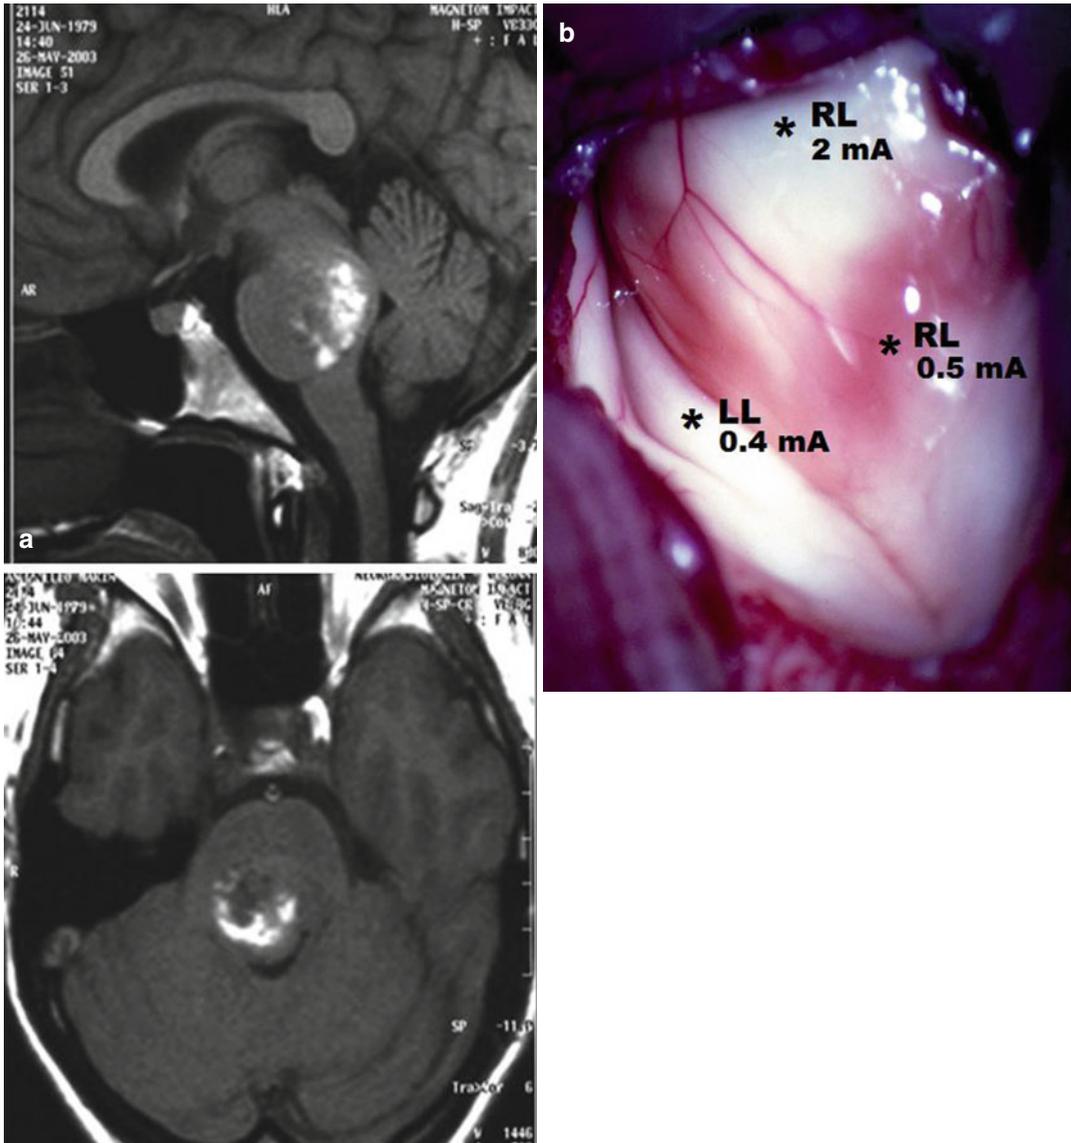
Displacement of facial nerve nuclei. (a) Sagittal and axial T1-weighted MR images of a bleeding upper pontine cavernoma. (b) Intraoperative view of the distorted floor of the fourth ventricle with no anatomical landmarks to identify the facial colliculi. Results of neurophysiological mapping are displaced. Responses from the right lower facial muscle, orbicularis oris, (RL) are recorded following monopolar stimulation with 2 mA (0.5 ms duration) at the *upper asterisk*. Responses from the right lower facial muscle, orbicularis oris, (RL) are
